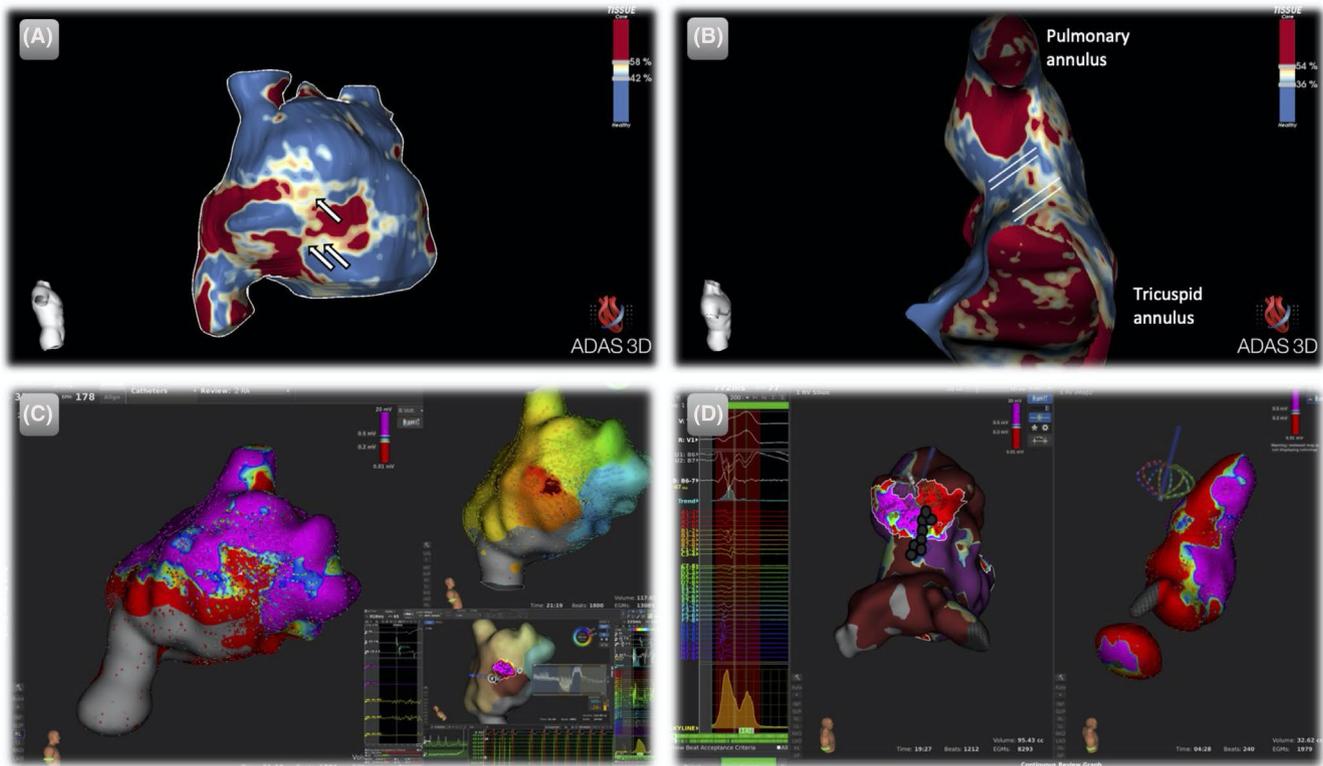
LGE-MRI 3D reconstruction (panels A and B) compared with Electroanatomic findings (panels C and D). Both atrium and ventricular cardiac MRI LGE areas were suggestive of post-surgical changes producing extensive replacement fibrosis, and suggest possible slow conducting isthmuses that could lead to re-entrant arrhythmias (Fig. A and B, white arrows and bars). Areas of slow conduction were localized during electroanatomic mapping and confirmed the presence of arrhythmia isthmus with adequate coincidence with the LGE-MRI. Right ventricle voltage and activation map was performed and identified areas of extensive and areas of slow conduction between both scars, concordant with CMR reconstruction (D). An ablation line between both low voltage areas was performed (black dots) to achieve non inducibility of VT
